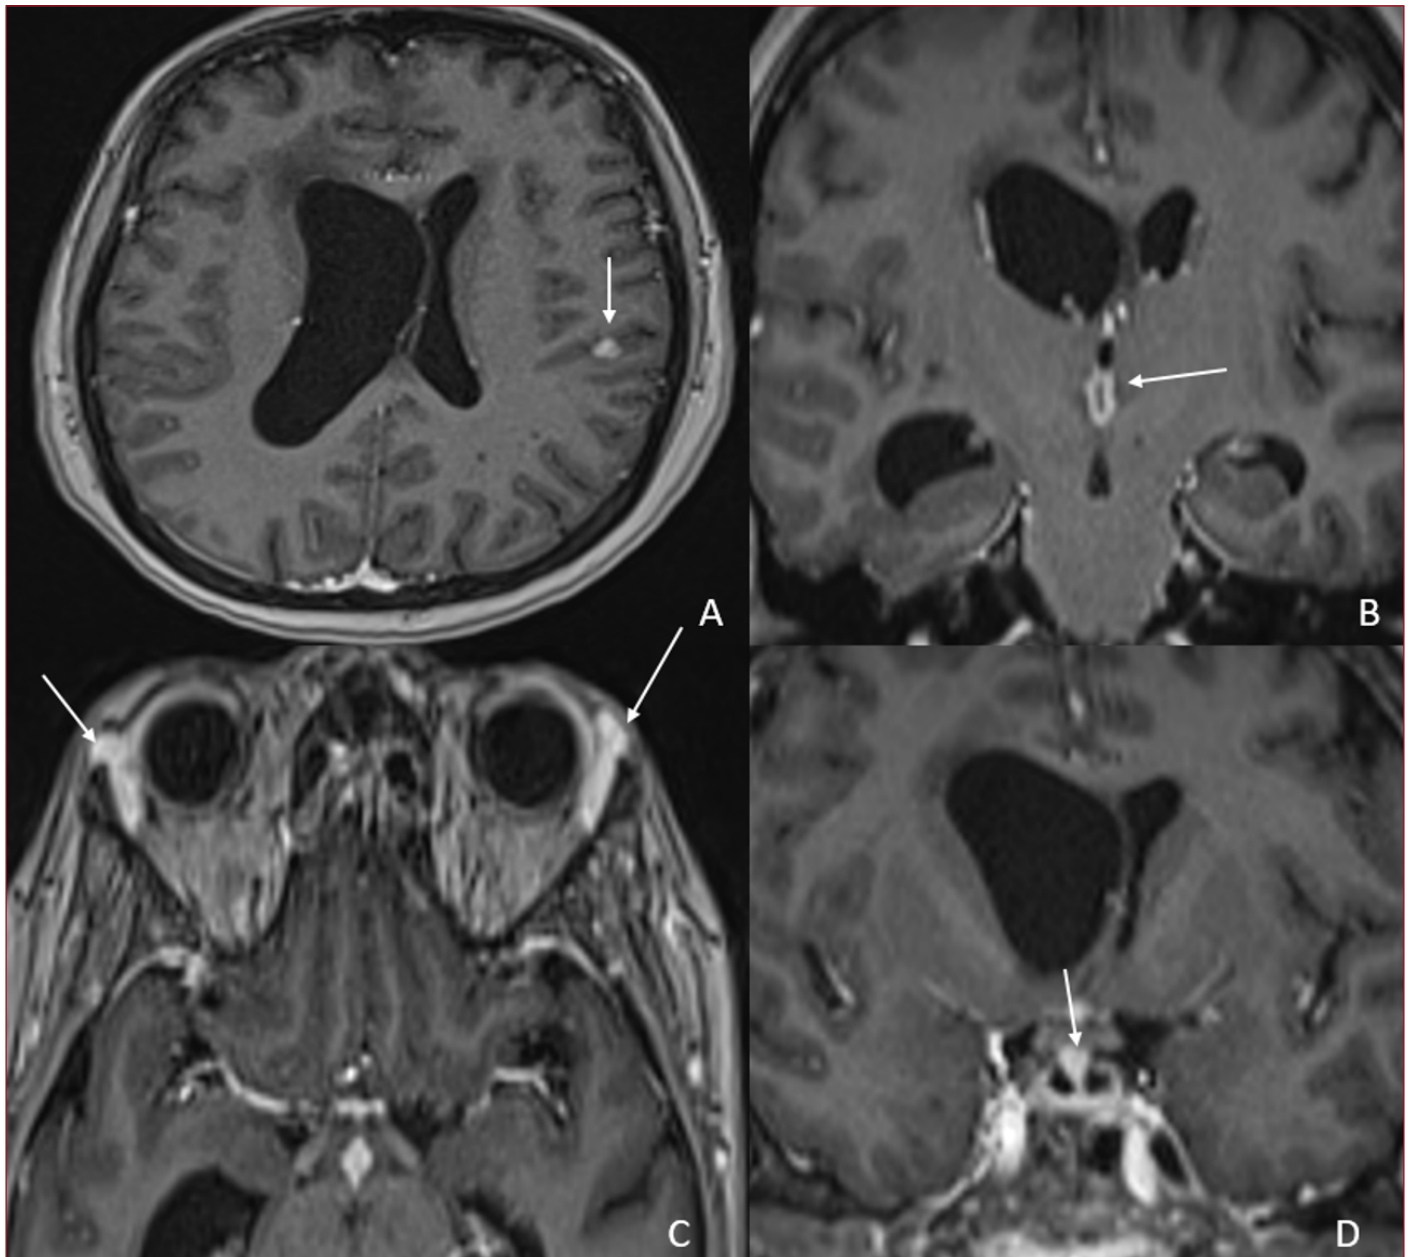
Contrast-enhanced brain magnetic resonance imaging (MRI). (A) Axial image demonstrates a small enhancing lesion in the left frontoparietal region (arrow). (B) Coronal image shows thickening and increased enhancement along the aqueduct of Sylvius and the wall of the third ventricle (arrow). (C) Axial image reveals bilateral lacrimal gland enlargement with intense enhancement (arrows). (D) Coronal image demonstrates thickening and enhancement of the pituitary stalk (arrow).
